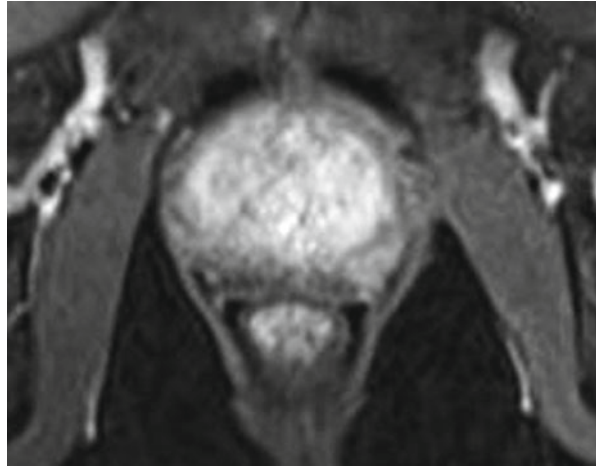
DCE-MRI perfusion map
